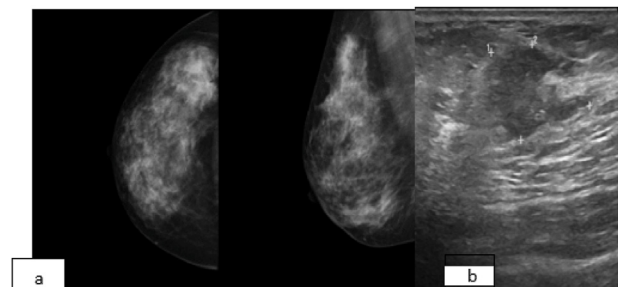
Infiltrating ductal carcinoma a female patient 33-year-old. A history of right breast lump. (a) Craniocaudal and mediolateral views of the right breast mammographic study display heterogeneously dense parenchyma which may obscure small lesions associated with irregular shaped hyperdense lesion with partially obscured margin seen in UOQ (ACR C) (b): ultrasound study. The UOQ shows an 11 o'clock irregular shaped hypo-echoic lesion measuring $(1.3 \times 1) \text{ cm}$.
